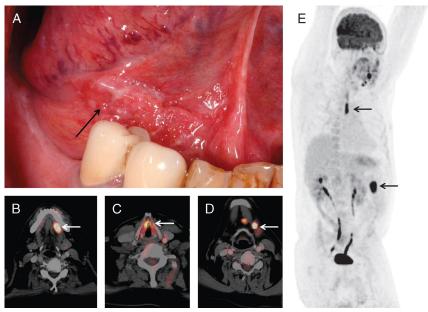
We report on a 53-year-old man who was referred with the suspicion of oral cavity cancer in the anterior floor of the mouth. The patient's history recorded tobacco and alcohol abuse as important risk factors for oral malignancies. Physical examination and panendoscopy revealed a tumor of the anterior floor of mouth on both sides (A, arrow) and a suspicious lesion in the right vocal cord. Cervical ultrasound and MRI indicated submandibular lymph node metastases. Subsequently, ¹⁸F-FDG PET/CT was performed for further staging and demonstrated intense correlating hypermetabolic foci in the anterior floor of the mouth and right vocal cord (B and C, arrows). In addition, FDG PET/CT revealed locoregional lymph node metastases in level 1 on the left side (D, arrow) and a hypermetabolic lesion in the esophagus (E, dotted arrow). A further suspicious focal tracer uptake was found in the colon (E, arrow).
